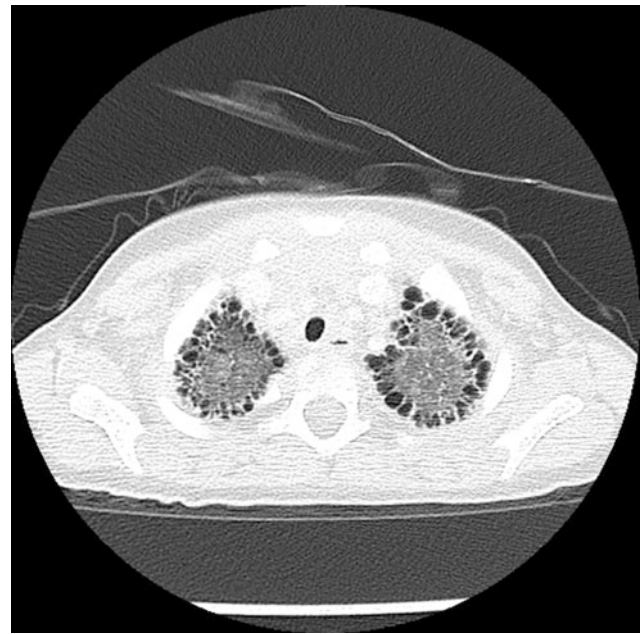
Growth abnormality. An axial chest CT image from a two-year-old with Down syndrome shows numerous bilateral subpleural cysts. Enlargement of the alveoli and alveolar ducts is particularly marked in the subpleural region in the lung growth abnormality related to Down syndrome
